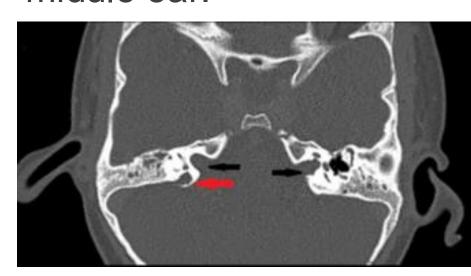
Computed tomography of the temporal bones; the red arrow marks the enlarged of the vestibular aqueduct; the inner ear canals are marked with black arrows.
